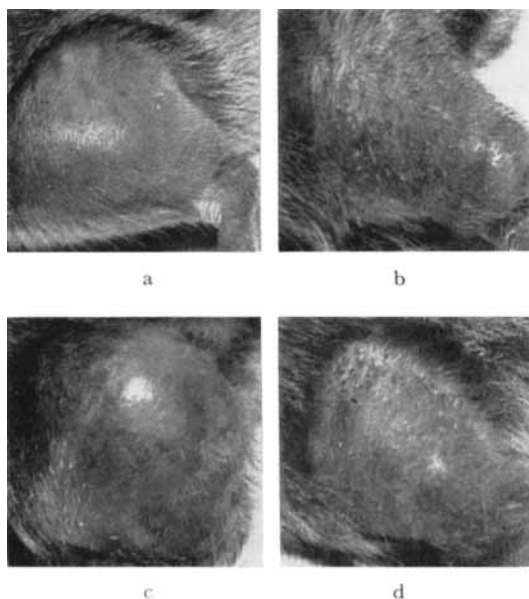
Thirty days post-irradiation with 250 keV roentgen. a) No irradiation. b) 2 000 rad. c) 3 000 rad. d) 4 000 rad.
